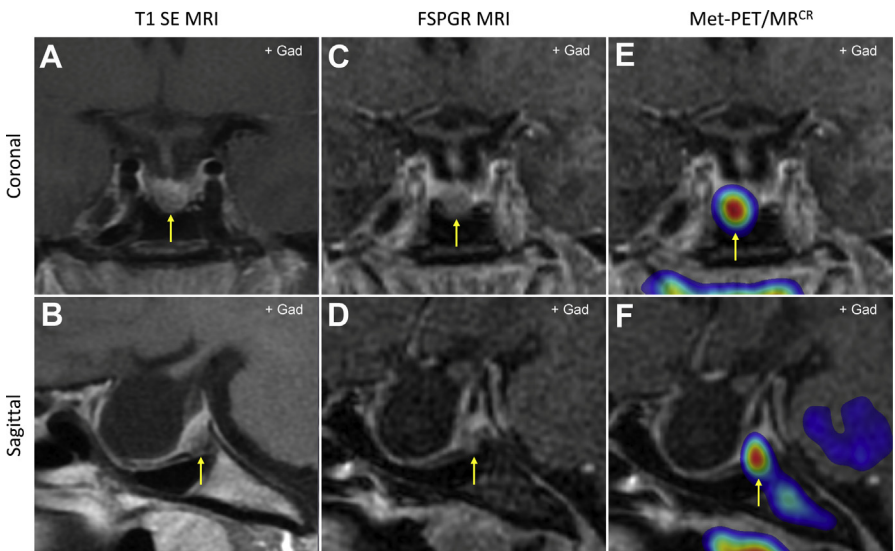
Localization of the site of early recurrence (at 8 months) following primary surgery in a patient with acromegaly (sparsely granulated tumor; MIB-1 proliferation index = 15%). (A, B) T1 SE MRI shows a largely empty sella, but with a possible area of abnormal tissue posterior to the site of insertion of the infundibulum (*arrow*). (C, D) Volumetric (FSPGR) MRI demonstrates a similar appearance. (E, F) Met-PET/MR^{CR} shows focal high tracer uptake at the suspected site of recurrence (confirmed at repeat TSS).
